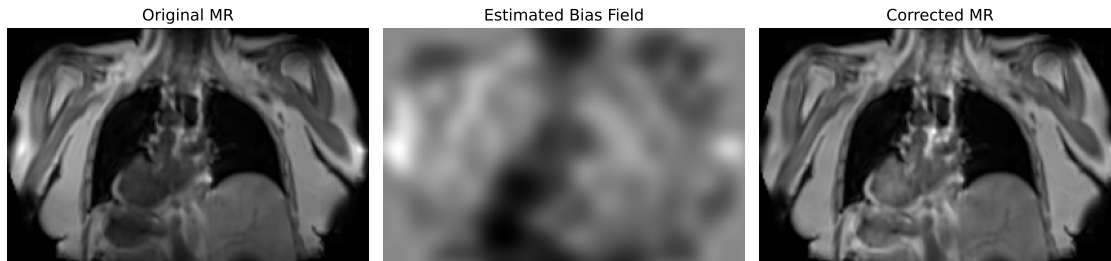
Bias field correction visualization (coronal slices). (left) Original MR image with intensity inhomogeneity. (middle) Estimated bias field. (right) Corrected MR image with improved homogeneity.
